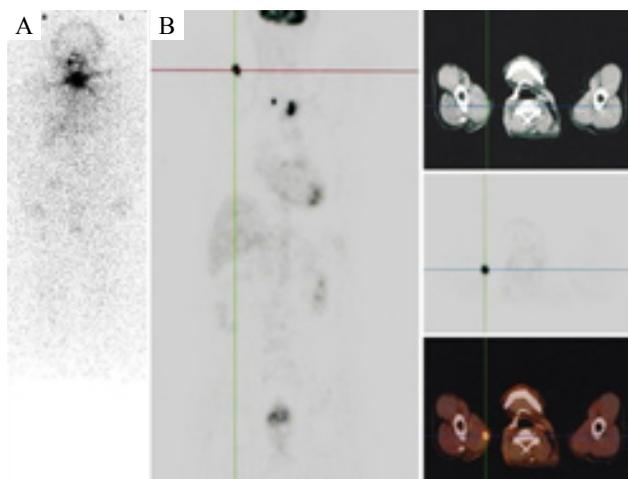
A patient with a history of PTC underwent a ^{18}F -FDG-PET/CT examination, because of a negative posttherapeutic ^{131}I -WBS image (A) but with elevated Tg level. Unsuspected muscle metastases were detected by ^{18}F -FDG-PET/CT (B, cross line). The ^{18}F -FDG-PET/CT was helpful in this case.
